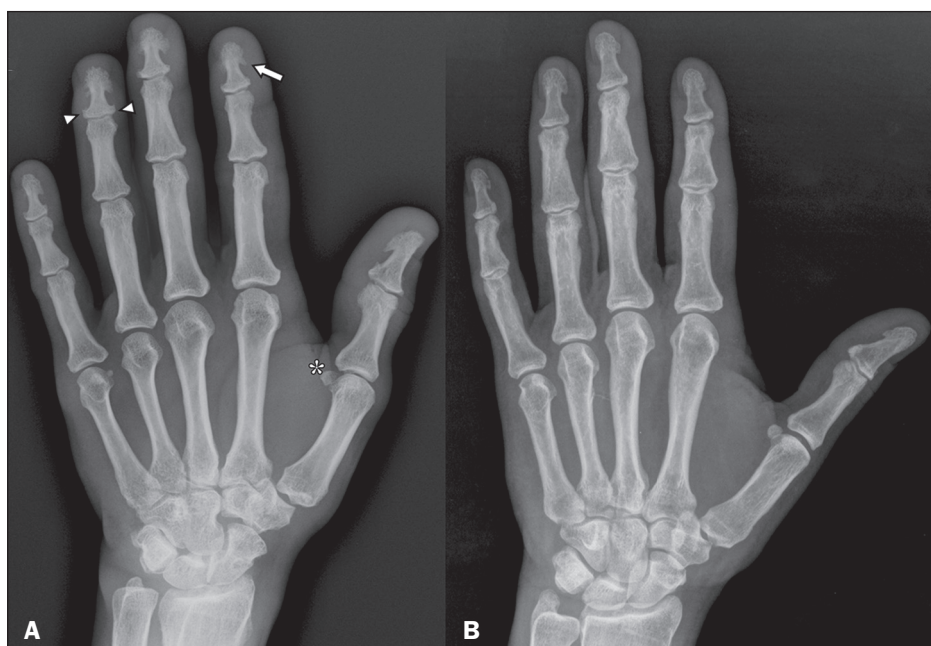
A: Conventional radiograph, in an anteroposterior view, of the right hand of a patient with acromegaly, showing hypertrophy of the terminal tufts of the distal phalanges, forming projections similar to spurs (arrow), as well as enlargement of the bases of those phalanges (arrowheads) and a slight increase in the size of the sesamoid bone (asterisk). Note also the prominence of the soft tissues around the fingers. B: Conventional radiograph, in an anteroposterior view, of the right hand of a healthy patient, for comparison.
